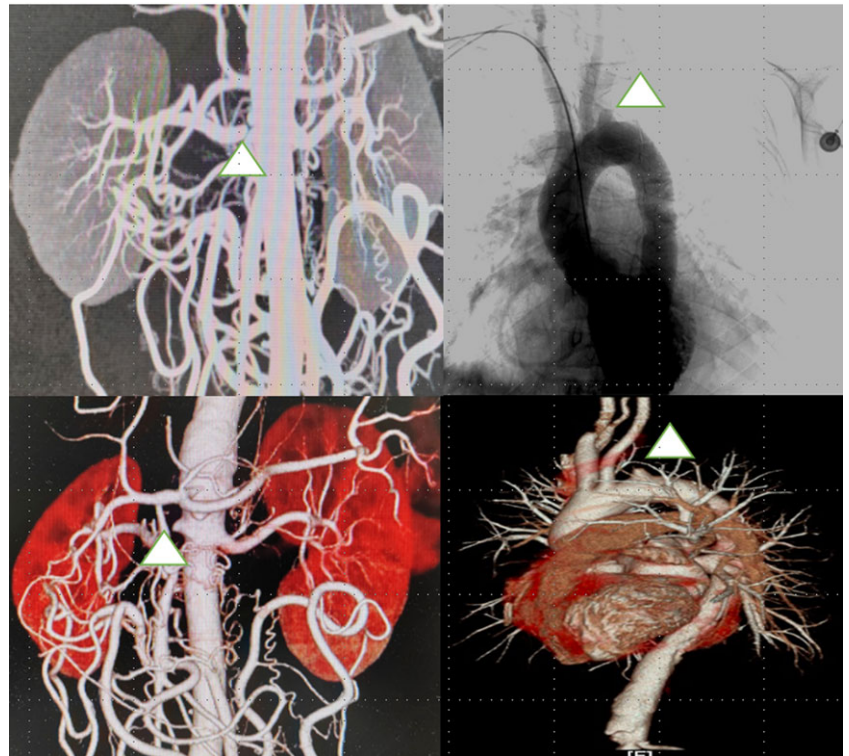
Right renal artery CT angiography and aortic angiography. Triangle showed the occlusion of the left subclavian artery and right renal artery.
